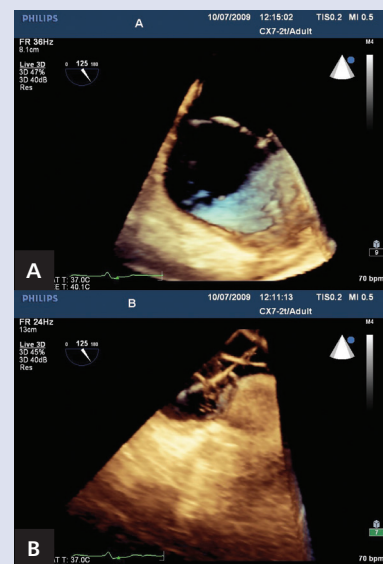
Real-time three-dimensional (3D) transoesophageal echocardiography (TEE) showing the fragment of atrial lead placed in the right atrial appendage (A) and the temporary ventricular lead running crosswise (B) (Philips® iE33 with live 3D software; X7-2t TEE probe)
